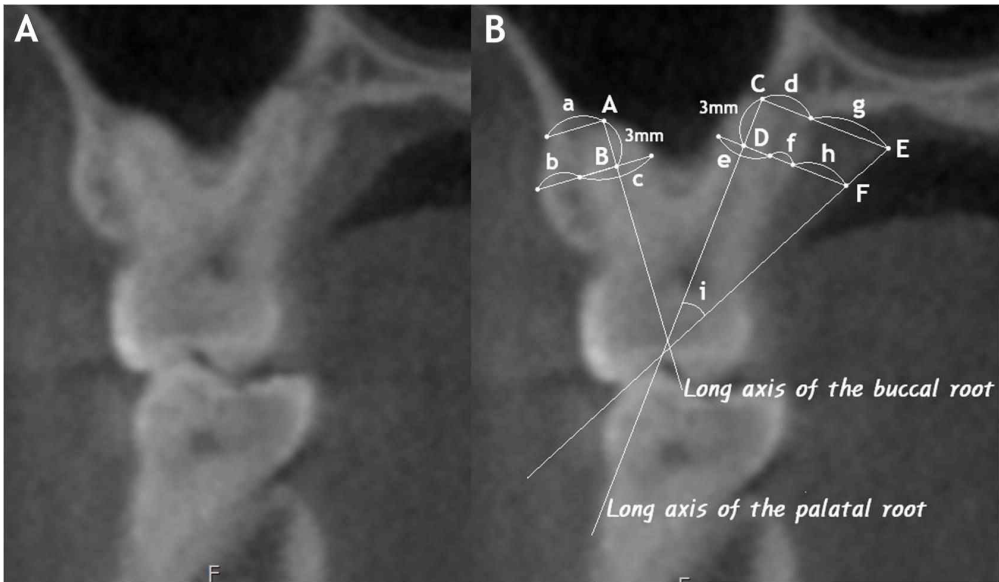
A) Coronal CBCT image selected for analysis. B) Measurements in the coronal CBCT image. A) Buccal root apex. B) 3mm below buccal root apex. C) Palatal root apex. D) 3mm below palatal root apex. E) Palatal soft tissue surface at the root apex level. F) Palatal soft tissue surface at the root-3mm level. a) Alveolar bone thickness from root apex to buccal bone surface. b) Alveolar bone thickness from resected root surface to buccal bone surface. c) Buccolingual width of resected buccal root section d) Alveolar bone thickness from root apex to palatal bone surface. e) Buccolingual width of resected palatal root section. f) Alveolar bone thickness from resected root surfaces to palatal bone surface. g) Palatal soft tissue thickness at the root apex level. h) Palatal soft tissue thickness at the root-3mm level. i) The angle between the straight line connecting E and F and the palatal root axis.
